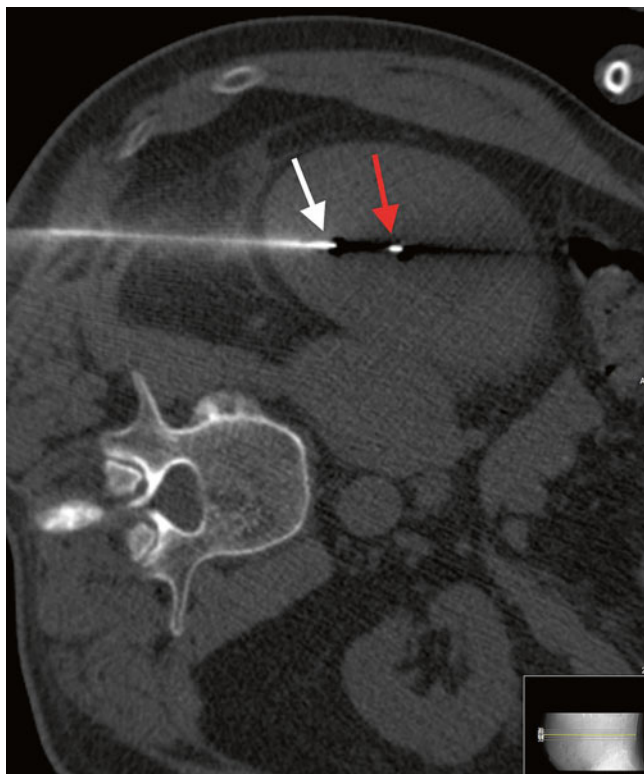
CT-guided renal biopsy. The image demonstrates a biopsy needle being placed percutaneously through the right posterior of the patient and into the inferior pole of the right kidney. The red arrow denotes the end of the biopsy needle. Note the dark spot between the part of the needle denoted by the red arrow and the white arrow. This indicates the section of tissue that will be biopsied
